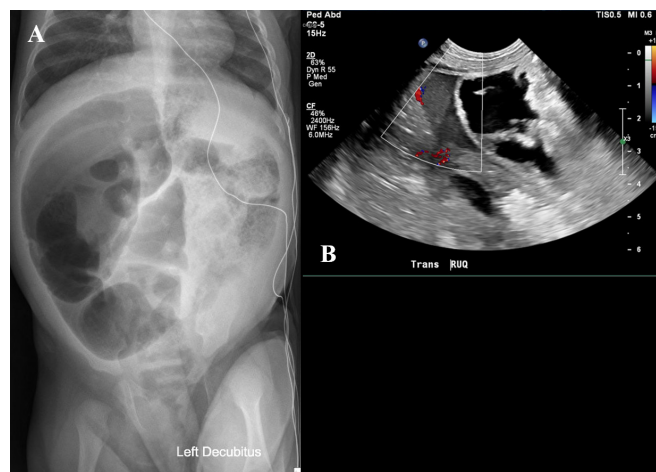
Radiographic findings. (A) Abdominal X-ray showing dilated bowel loops and air-fluid levels. (B) Ultrasound abdomen showing small complex fluid collections. RUQ, right upper quadrant
